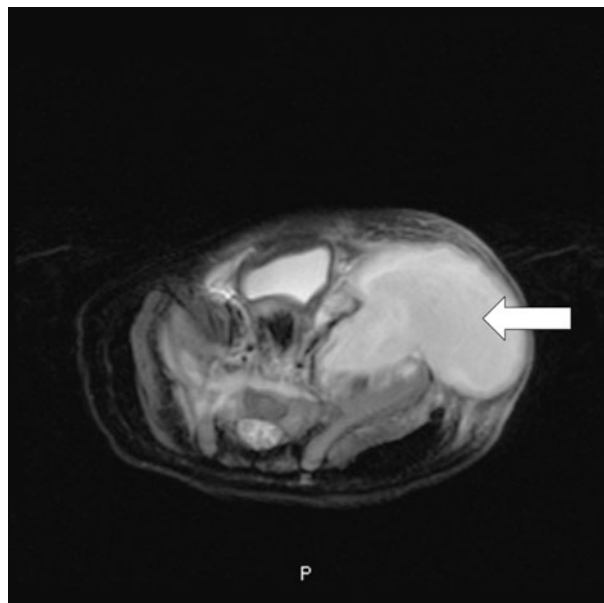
Magnetic resonance image of a retroperitoneal lymphatic malformation presenting as an asymptomatic abdominal mass in a newborn (arrow).
